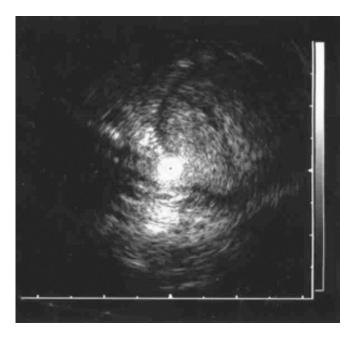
Endorectal ultrasound (12 MHz miniprobe) showing a hyperechoic, submucosal mass measuring 21.5 x 16.1 mm.
